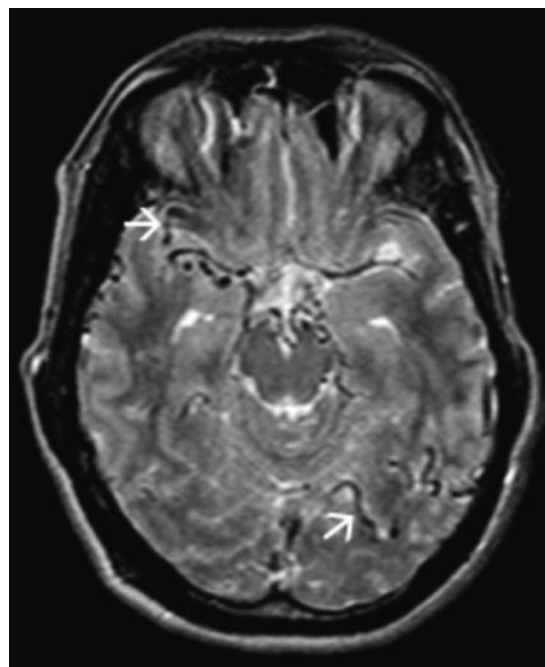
T2-weighted axial MRI of the brain showing direct communication of one branch of the middle meningeal artery with dural vein. Prominent vessels are seen in the region of the left occipital lobe and ambient cistern.
